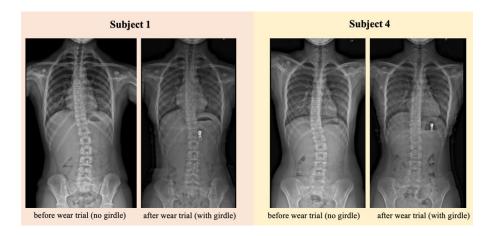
Radiographic results of Subjects 1 and 4.
